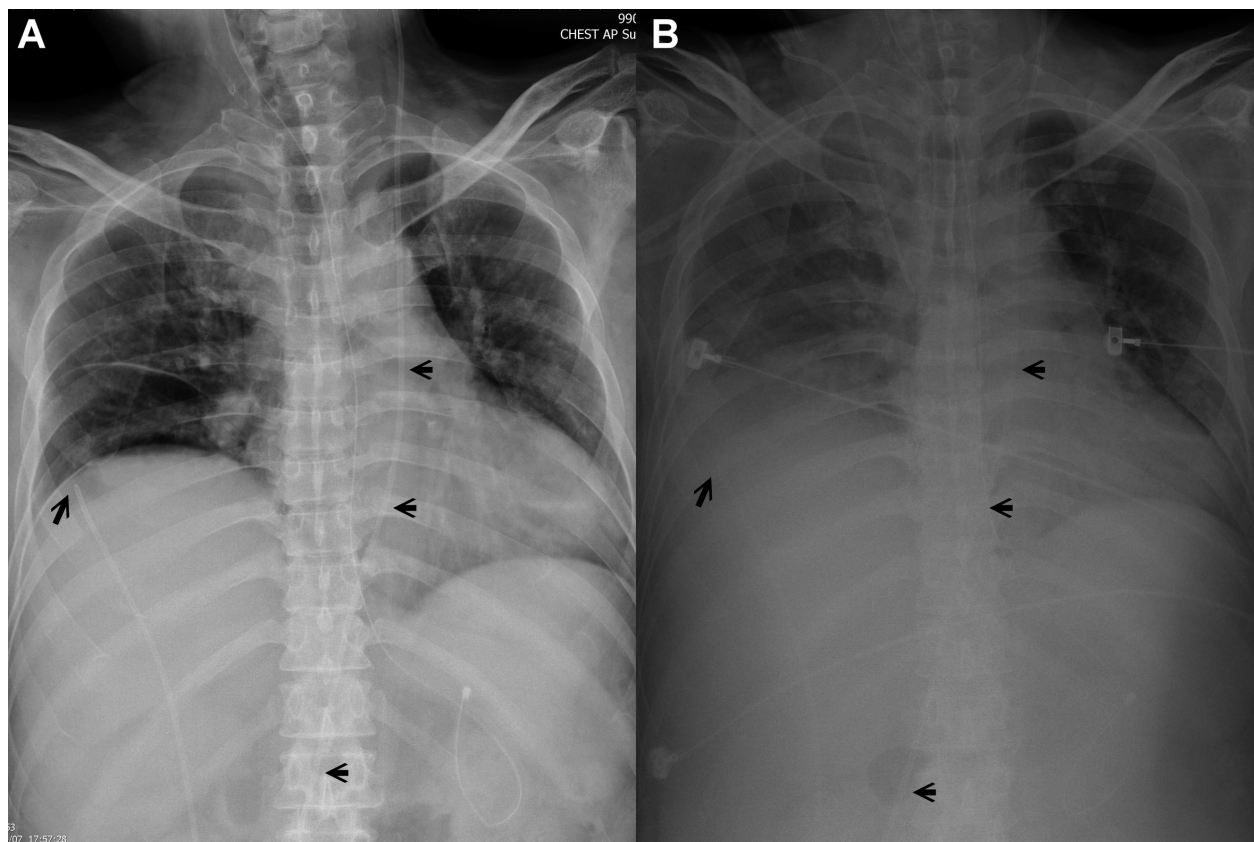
Chest radiography. (A) One and 1 half month after VP shunt insertion. The short arrowheads denote the course of the VP shunt and the long arrowhead the distal tip of the VP shunt. Note that the distal tip of the VP shunt was just beneath the right-side diaphragm. (B) Two days later, right-side pleural effusion appeared and the patient developed dyspnea.
